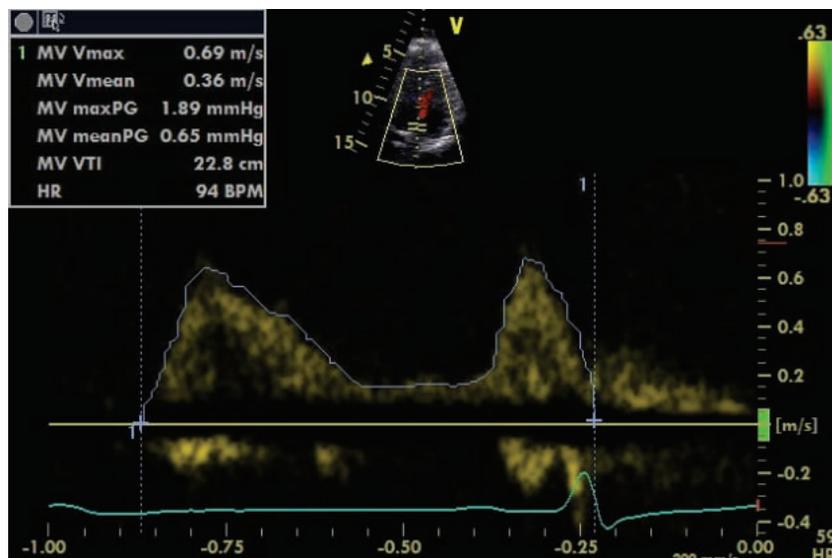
Echocardiographic measurement method of Mi-VTI.
